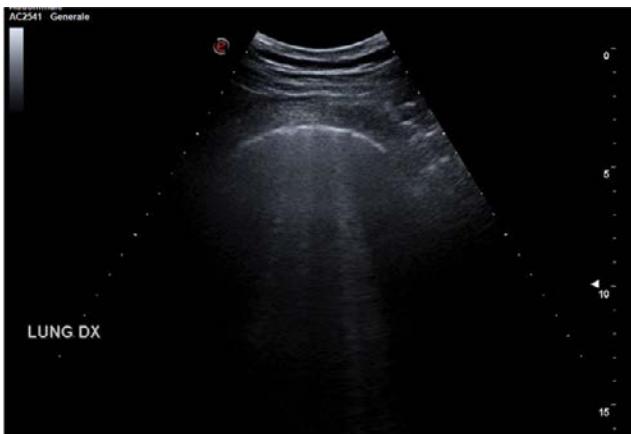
Lung ultrasound after CPAP: non-coalescent B lines and even lung fields with pattern A.
